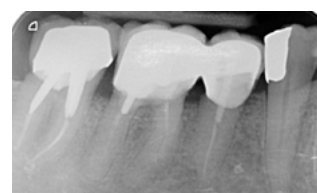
Postoperative X-ray check
